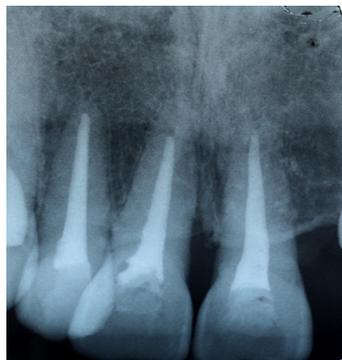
One-year follow-up radiograph.
